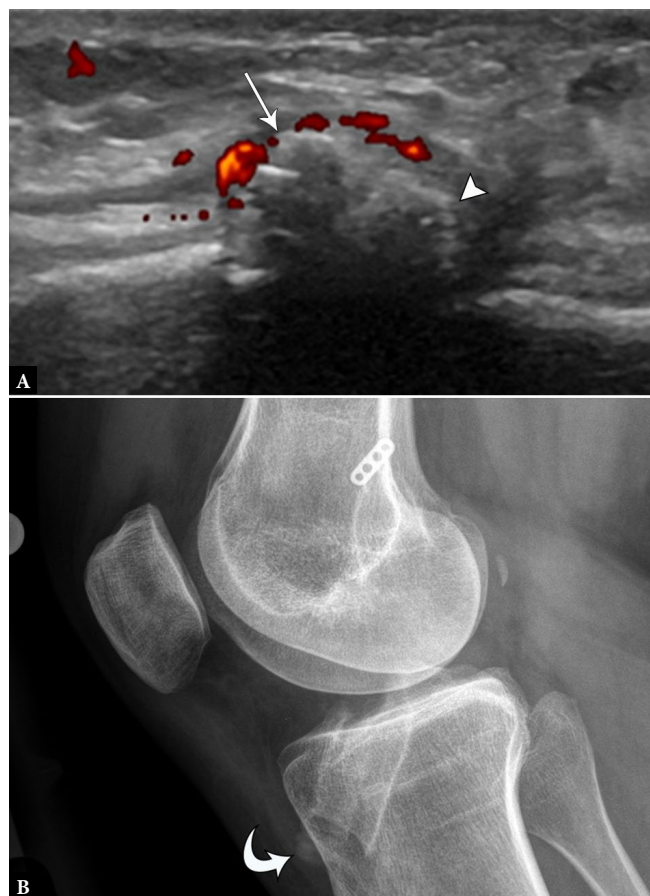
25-year-old female with anterior tibial pain and palpable lump following ACL reconstruction. A. Longitudinal power Doppler US image of the anterior tibial cortex in the area of focal pain identifies a protruding interference screw (arrow) with adjacent hyperemia and reactive bone formation (arrowhead). B. Follow-up knee radiograph identifies proud interference screw (curved arrow) corresponding to US findings
